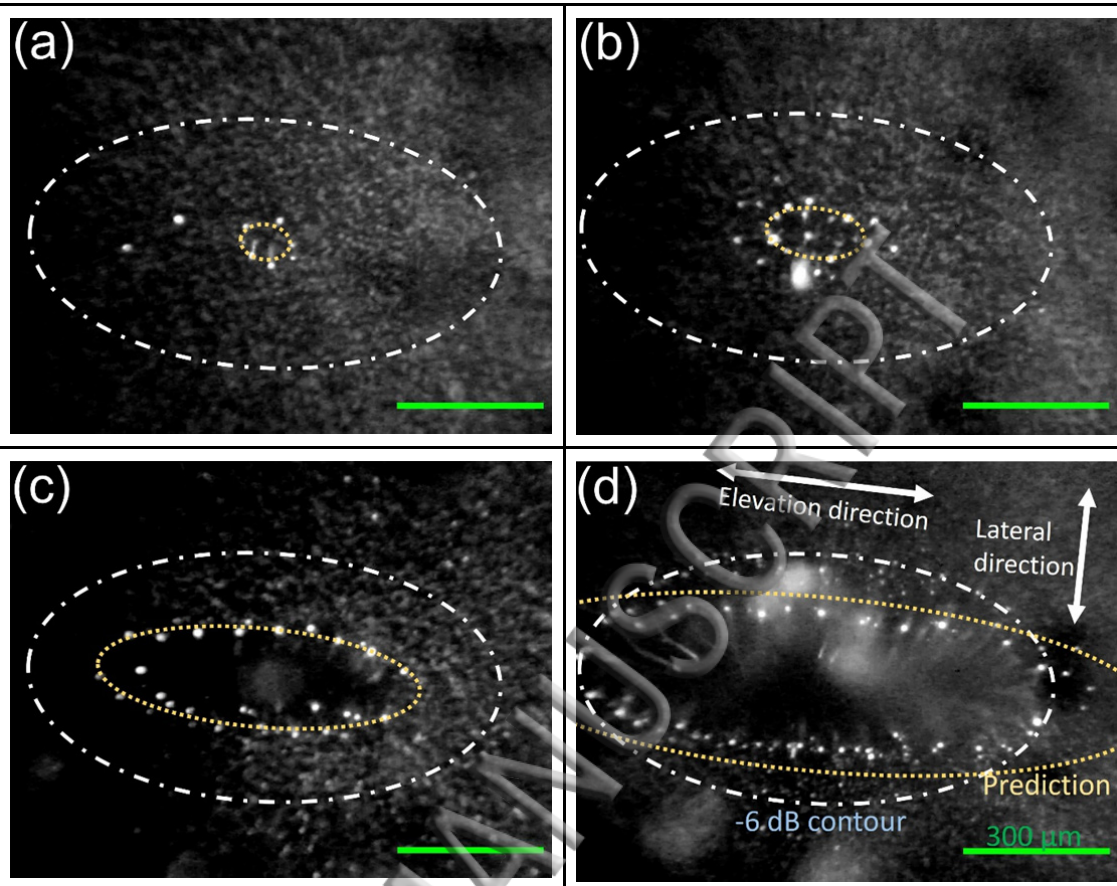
Delivery spot in the culture plate following a focused ultrasound pulse at various peak negative pressure a) 2.6 MPa b) 2.7 MPa c) 3.2 MPa d) 5.1 MPa (scale bar = 300 μm , dotted blue line represents the -6dB maximum pressure contour and the dotted yellow line is activation pressure threshold contour). The droplets are depleted in the release spot and, following radiation pressure, the resulting large bubbles or droplets are collected on its circumference. The yellow ellipse correspond to the release spot predicted from the activation pressure threshold and the white ellipse correspond to the full-width at half maximum of the focal spot profile. e) Experimental spot size, in the lateral and elevation direction, increasing with the peak pressure.
